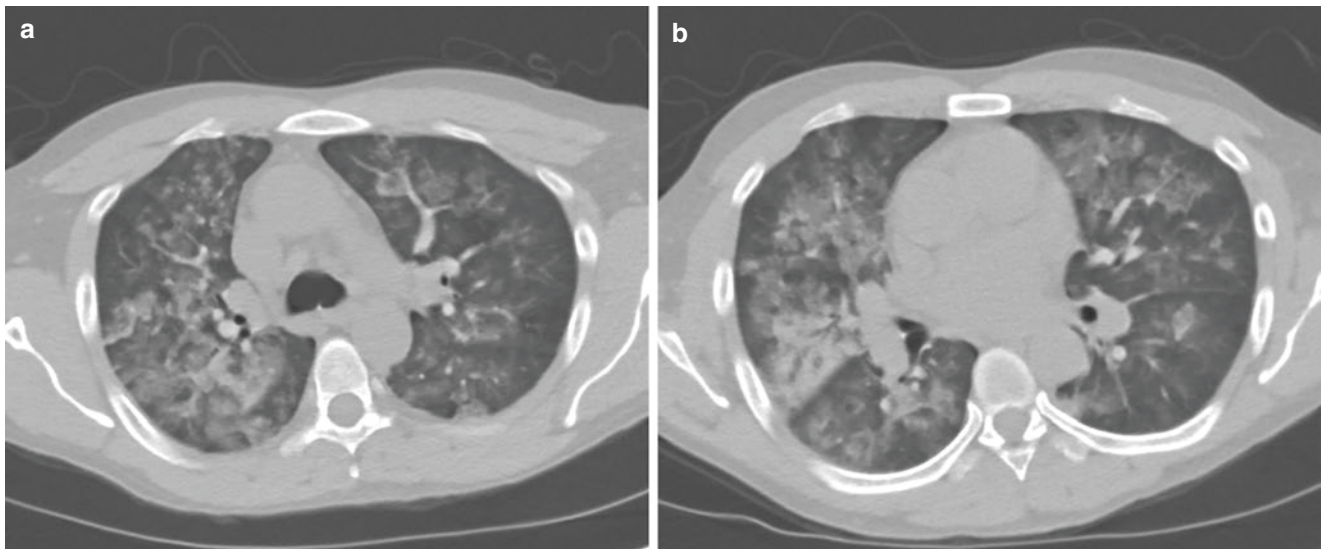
(a, b) Chest CT images performed after hemodialysis showing diffuse bilateral alveolar opacities
